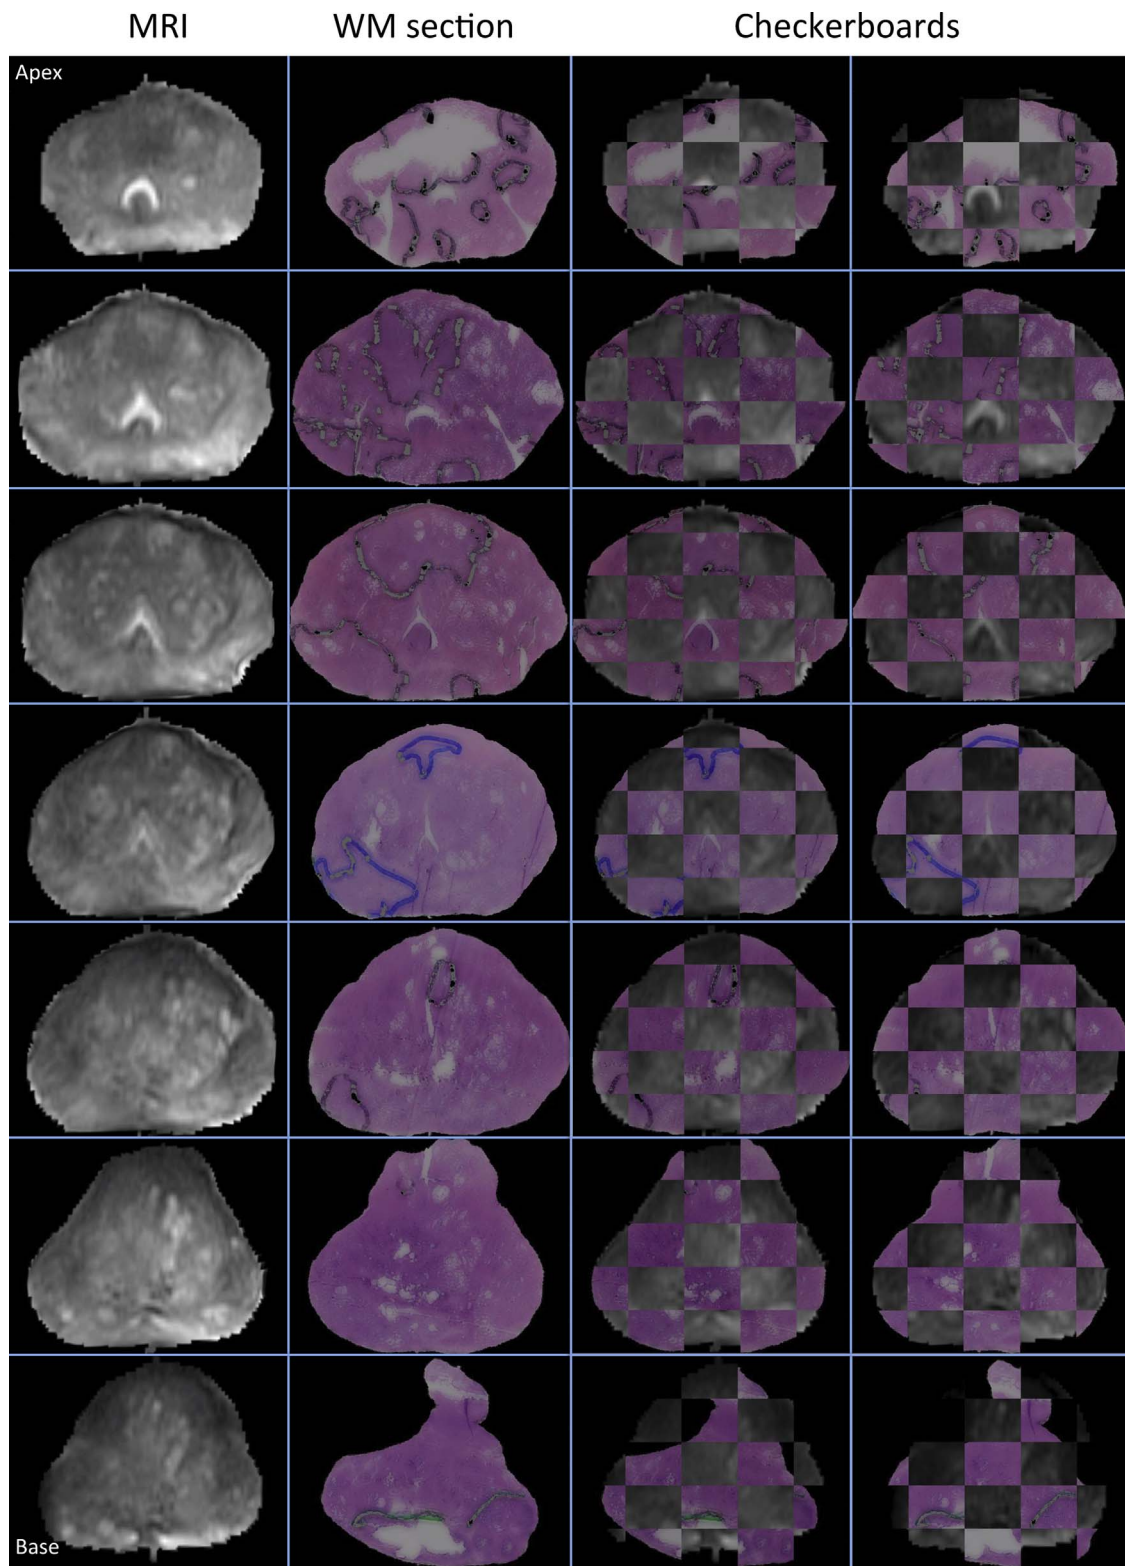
Slicewise comparison of registered MRI (first column), and the corresponding WM sections (second column) for patient no. 8. First row show the slices closer to the apex, and last row closer to the base. Registration accuracy assessment using checkerboard images are shown in 3rd and 4th columns.
